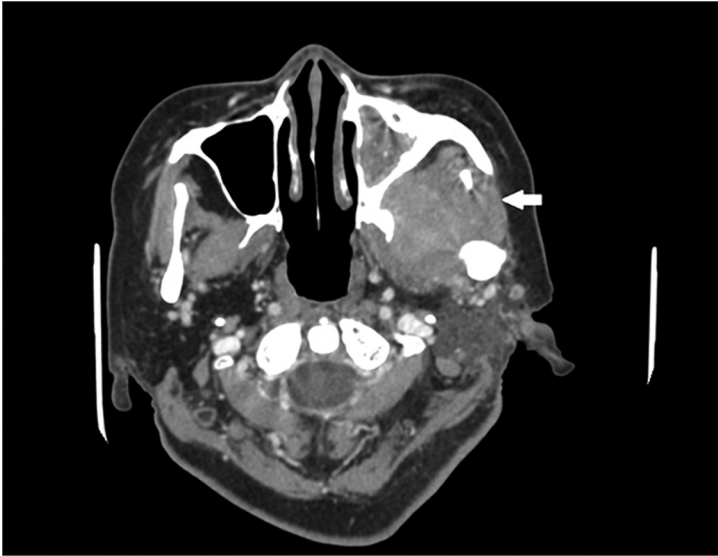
CT of a 60-year-old female (case 16) with a left pterygopalatine fossa and maxillary sinus lesion. The pre-procedural enhanced CT showed a diffuse lesion (arrow). The biopsy showed chronic inflammation of muscle and fibrous tissues. A poorly differentiated mucocystic carcinoma was diagnosed by surgical resection.
